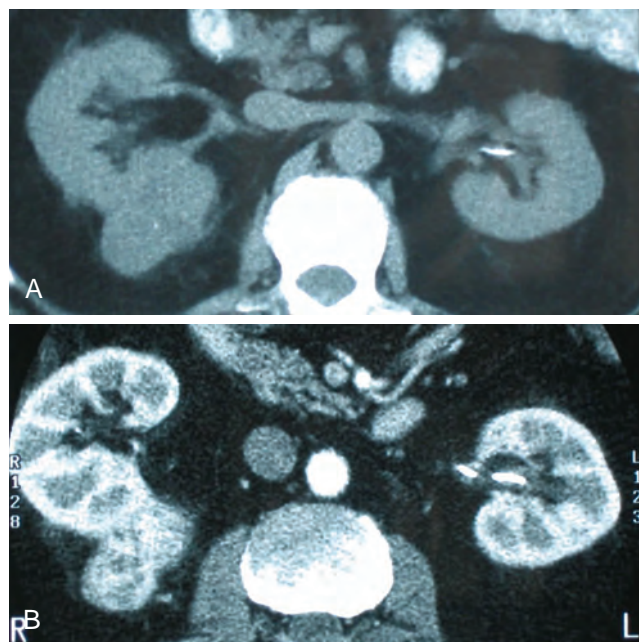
A, Computed tomography (CT) scan without administration of contrast material shows solid, right posterior renal mass. B, After administration of the contrast agent, CT scan shows that the mass enhances more than 20 HU and is thus highly suggestive of renal cell carcinoma (RCC). This mass was excised and confirmed to be a clear cell RCC. (Courtesy Dr. Terrence Demos, Maywood, IL.)
